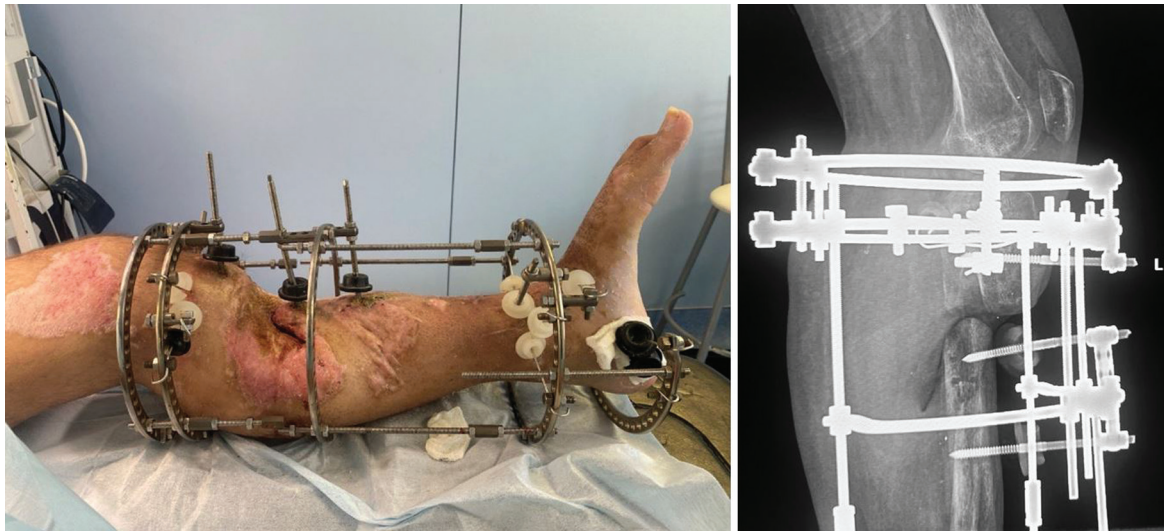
Photo and radiograph of the left lower leg at the approximation of the proximal and transported fragments (invagination)
